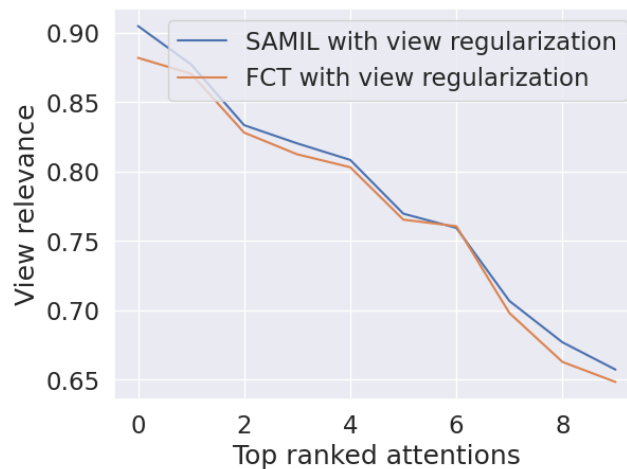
Average view relevance scores for the top 10 attended images across the test set in split 3 of the Tufts Medical Echocardiogram Dataset. Values close to 1 indicate that clinically relevant views (parasternal short axis and parasternal long axis) were used for the AS predictions.
